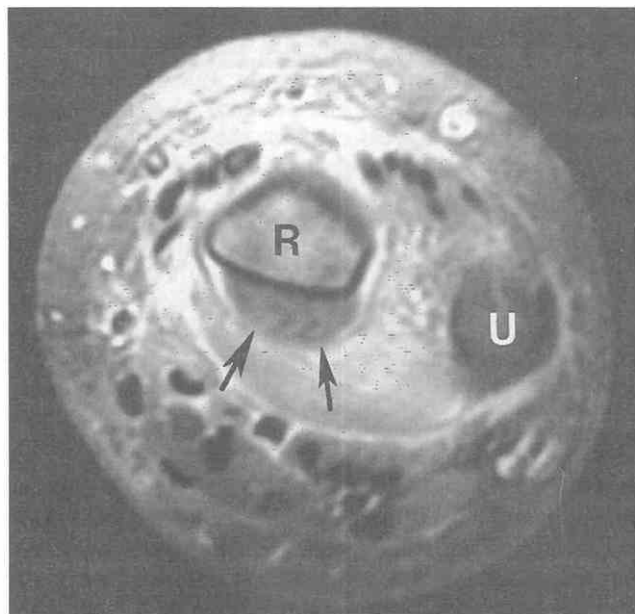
Acute osteomyelitis of the distal radius (R) in an 8-year-old girl. Axial postgadolinium T1-weighted image (TR = 500 msec, TE = 14 msec) with fat saturation shows a subperiosteal abscess (arrows). Marrow of the radius enhances relative to the marrow of the ulna (U). Enhancement is also seen in adjacent soft tissues.
